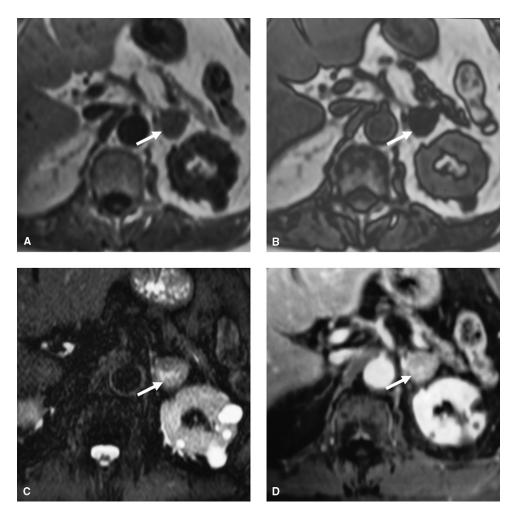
Left adrenal metastasis from lung carcinoma. Unenhanced T1-weighted in-phase (A) and out-phase (B), fat suppressed T2-weighted (C), and enhanced T1-weighted (D) MRI axial acquisitions. A 2-cm, round mass with well-defined margins (white arrow) is evident (A–D). The nodule has low signal intensity and, in the sequences based on the chemical shift phenomenon (A, B), it does not show an apparent signal change between in-phase (A) and out-phase (B) acquisitions. The cellular density, water content, and vascularization are evidenced by medium–high signal intensity on T2-weighted acquisition (C) and by clear enhancement after gadolinium chelates CA administration (D).
